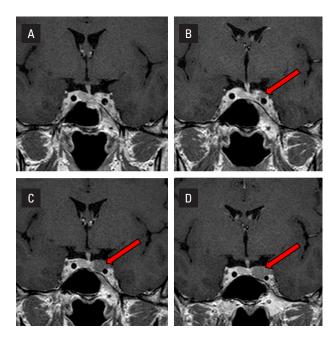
A. Coronal T1-weighted post-gadolinium pituitary magnetic resonance imaging (MRI) after initial transsphenoidal surgery; B. Coronal T1-weighted post-gadolinium pituitary MRI after second incomplete transsphenoidal surgery; C. Coronal T1-weighted post-gadolinium pituitary MRI demonstrates corticotroph tumour progression during long-term treatment with osilodrostat; D. A subsequent MRI of the pituitary gland after 6 weeks showed further progression of the tumour
